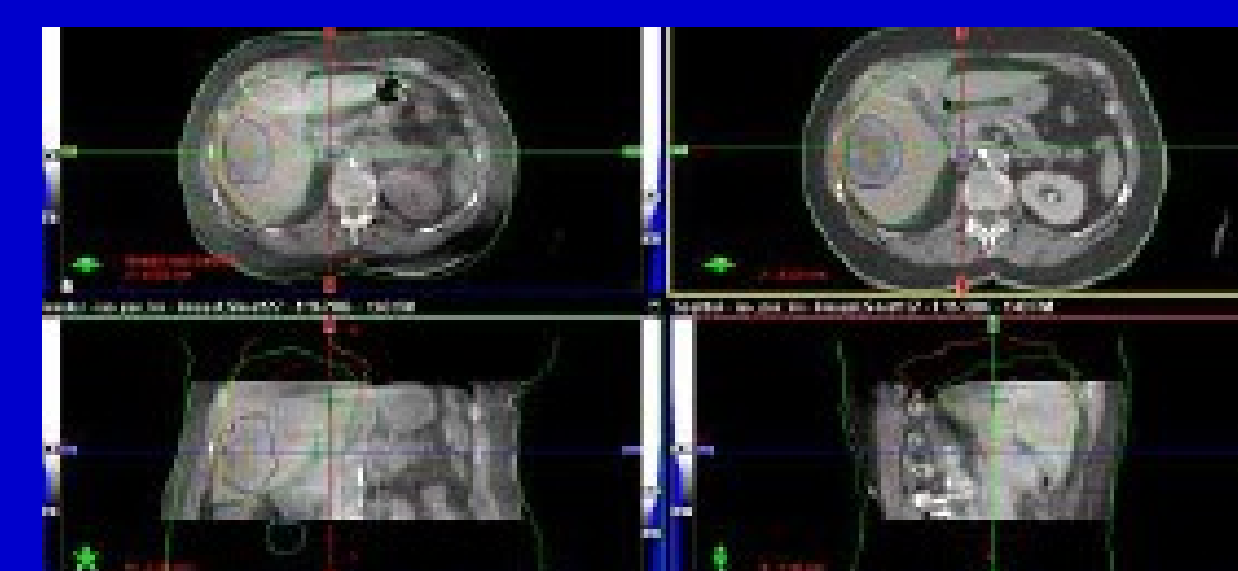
CBCT for the liver case after matching with planning CT (shown with contours).
